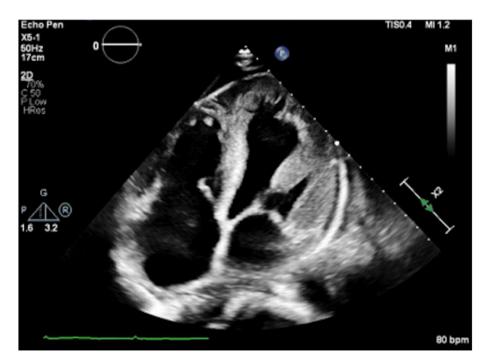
Echocardiogram indicated significant left ventricular hypertrophy, mildly thickened mitral and tricuspid valve leaflets, and small pericardial effusion.
